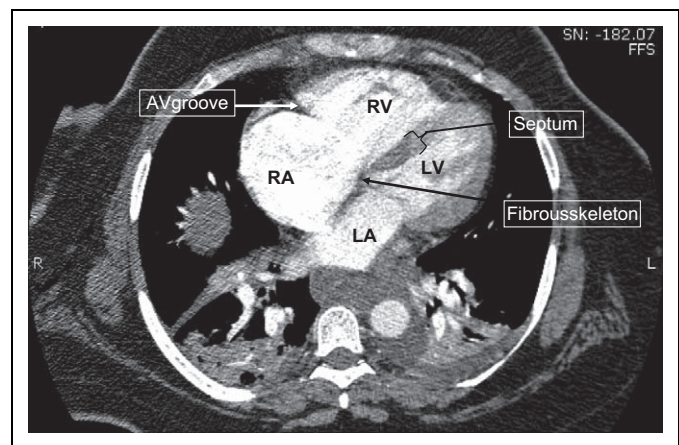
Computed tomographic pulmonary angiography (CTPA) with 4 chambers visualized demonstrates RV enlargement, RA enlargement, and flattening of interventricular septum in a patient with PE. RV indicates right ventricle; RA, right atrium; LV, left ventricle; LA, left atrium.
